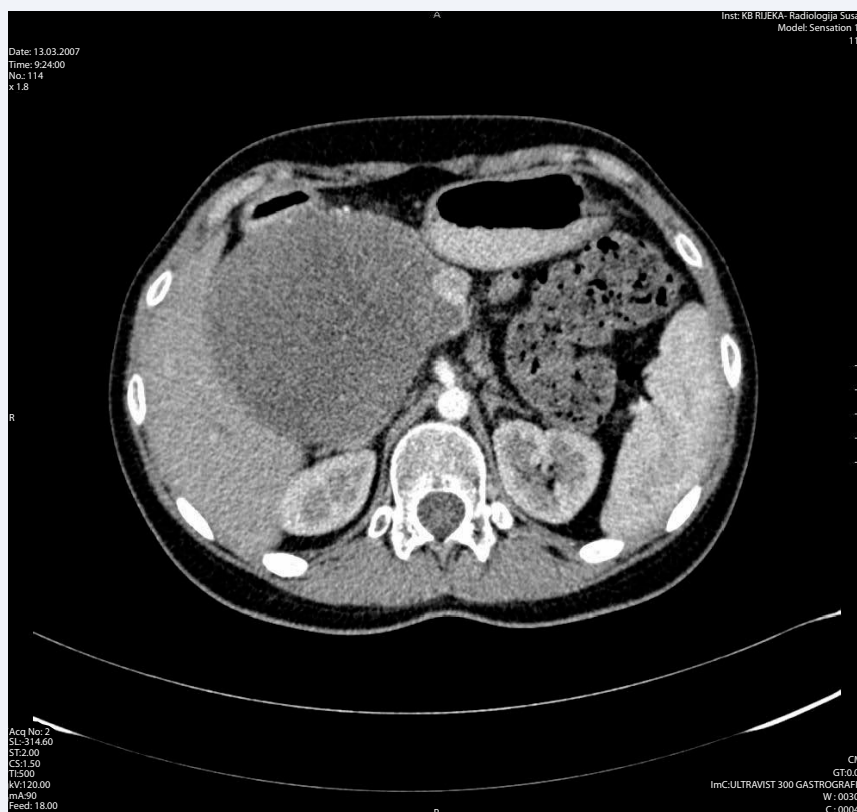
Abdominal computed tomography suggestive of liver lesion.
